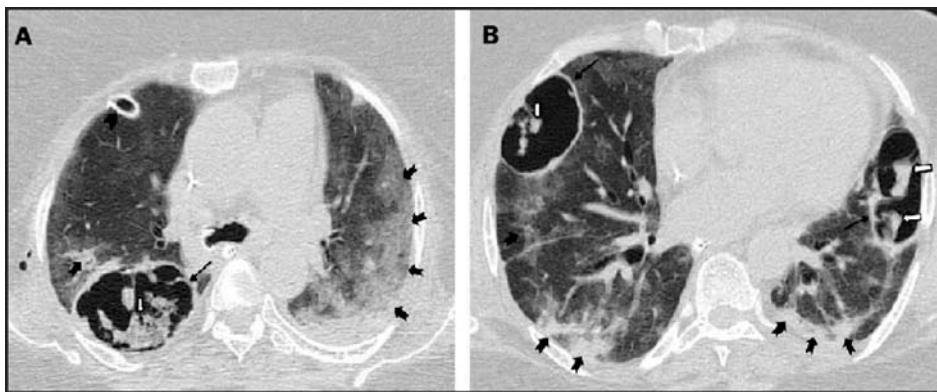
High resolution computed tomography of the chest shows multiple thick walled cavities in bilateral lung field (shown with white arrows); and extensive ground glass opacification are shown with black arrows.
